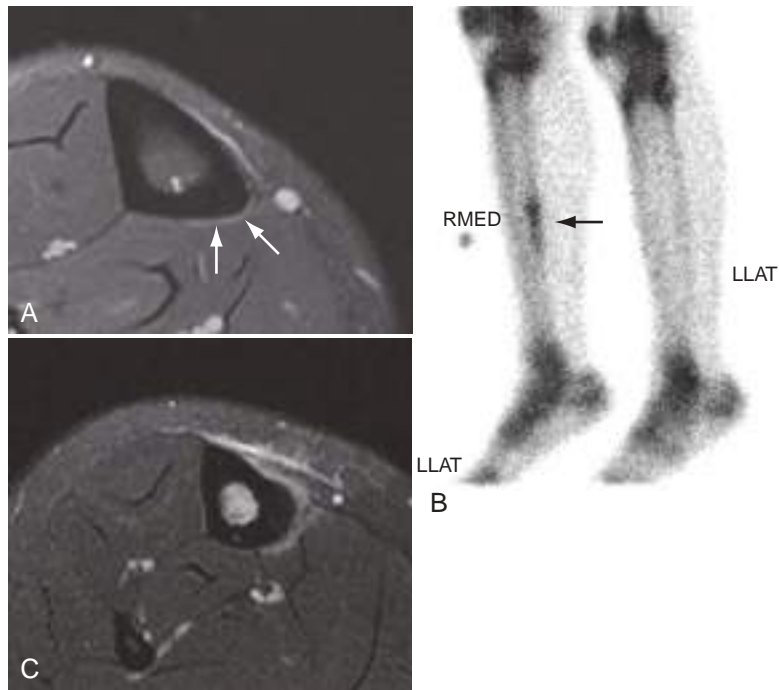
Tibia shin splint progressing to stress fracture in a long-distance runner. (A) Initial axial fat-suppressed T2-weighted MR image shows subtle periosteal edema on the posterior tibial shaft (*arrows*). (B) Bone scan obtained the next day confirms classic stress reaction pattern with localized longitudinal tracer uptake in the posterior proximal tibial cortex (*arrow*). Despite these findings, the patient chose to continue running. (C) Repeat MRI using the same sequence 3 weeks later shows intense bone marrow and periosteal edema of a stress fracture.
